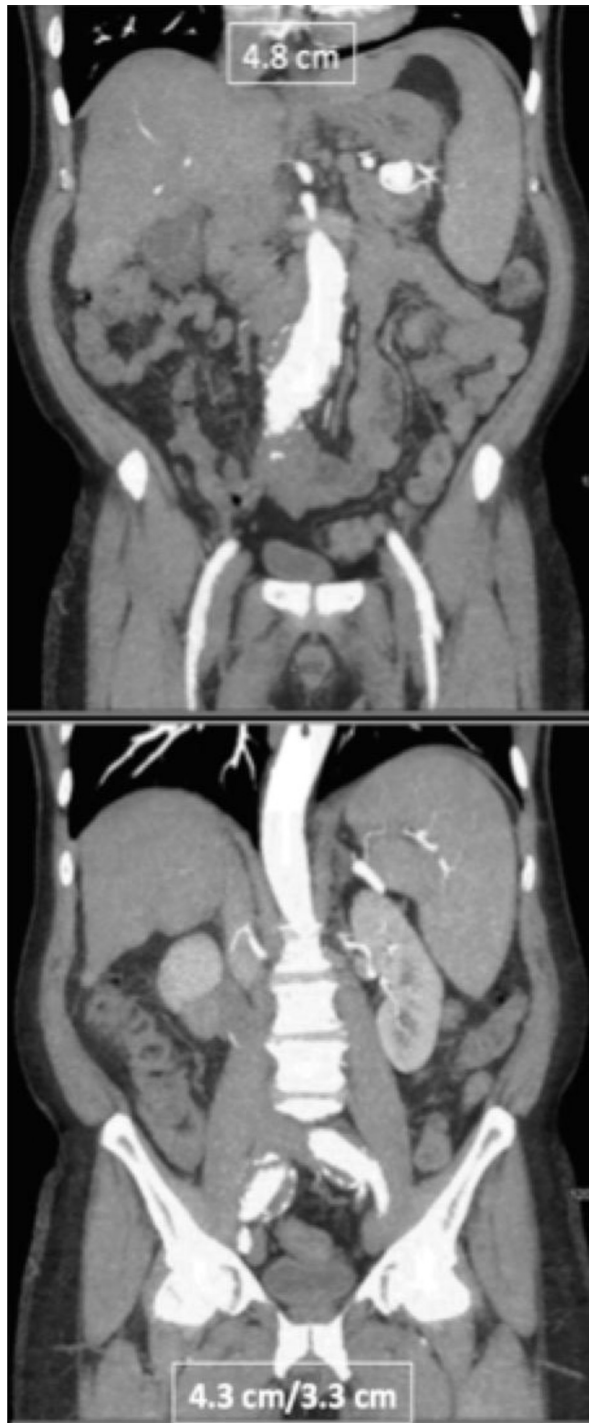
Computed tomography angiography of the abdomen and pelvis, June 2014.
